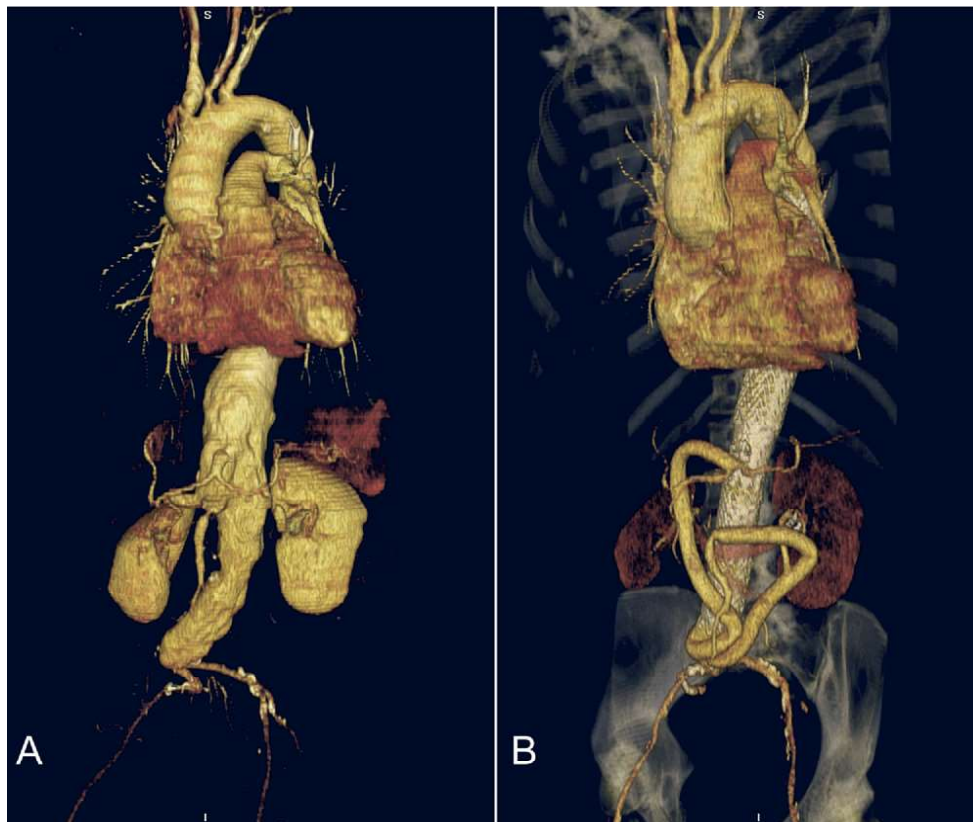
Pre- and postoperative computed tomography angiography (CTA) showing a thoracoabdominal aortic aneurysm Crawford type III being treated successfully with hybrid procedure.
